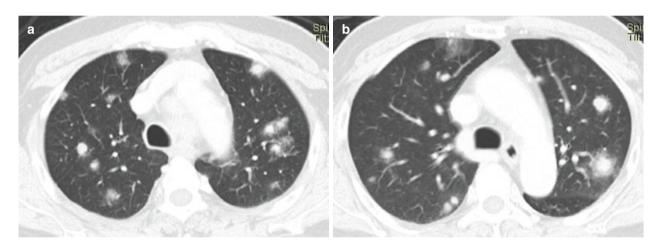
A 72-year-old man with hemorrhagic metastases from papillary thyroid cancer. (a, b) Axial CT images show multiple nodules with a "halo" of ground-glass opacities
